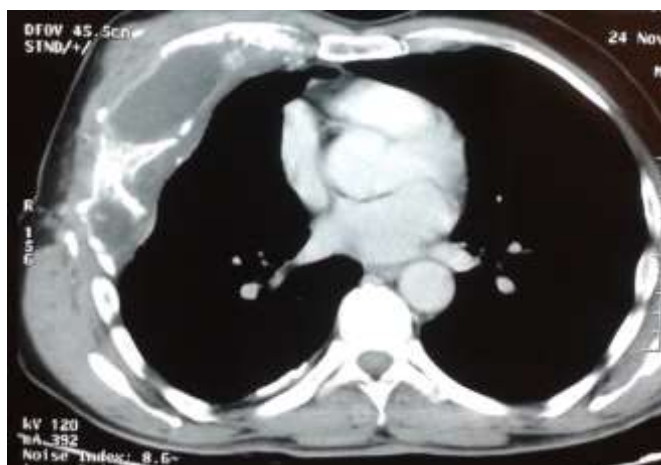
Chest CT showing an osteolytic process of the 3rd and 4rd rib with a fluid bone collection.
